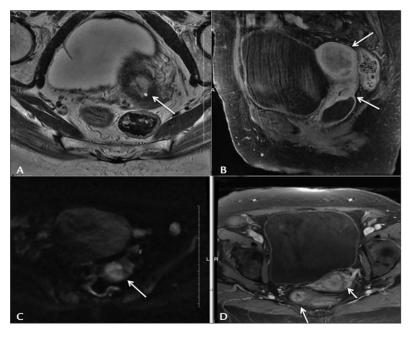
Imaging findings: T2-weighted MRI sequence on axial (A) view shows slightly hyperintense lesion occupying the cervix (arrow); T1-weighted MRI sequence with fat saturation after gadolinium injection, sagittal (B) view, two lesions occupying the endometrial (large arrow) cavity and cervix (small arrow) with peripheral enhancement after contrast administration; DWI-weighted (C) T1-weighted sequences with fat saturation after contrast injection (D) reveal lesion with restricted diffusion in the uterine cervix.
